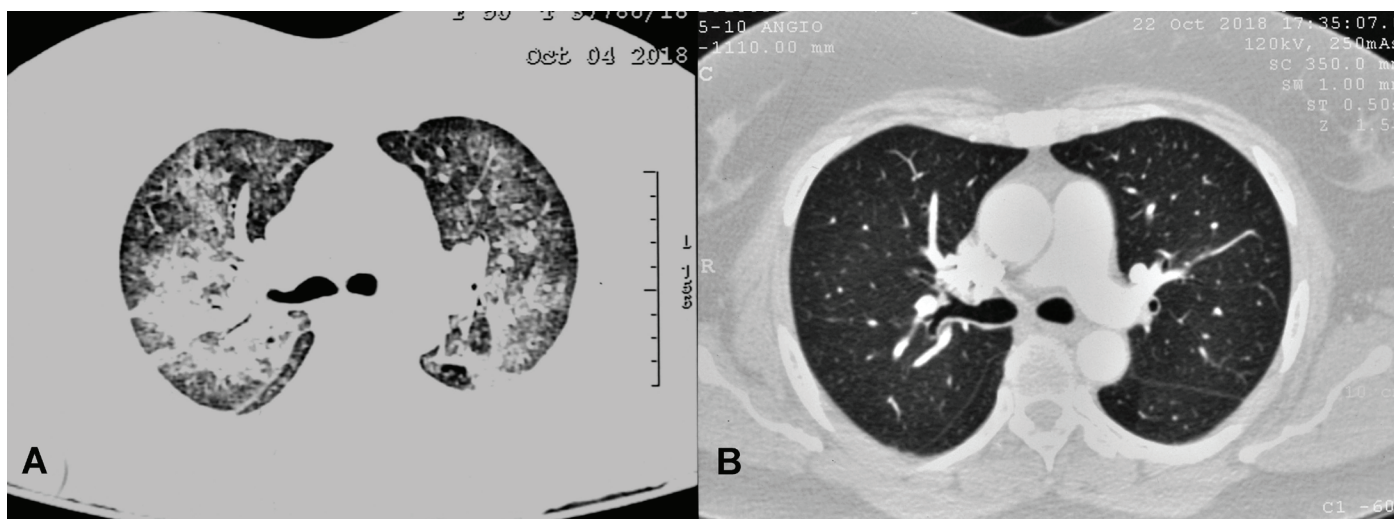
Chest radiograph (A) at presentation showing diffuse bilateral symmetrical basal predominant infiltrates, with peripheral sparing. (B) Unremarkable chest radiograph obtained during the second hospitalisation for breathlessness.
